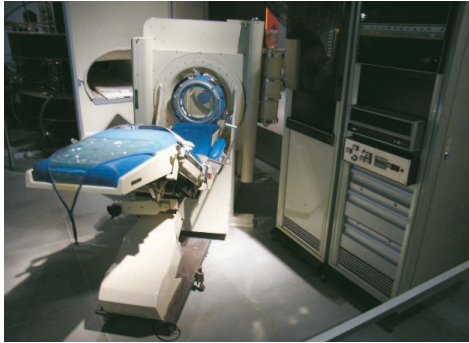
A historic CT Scanner of EMI
